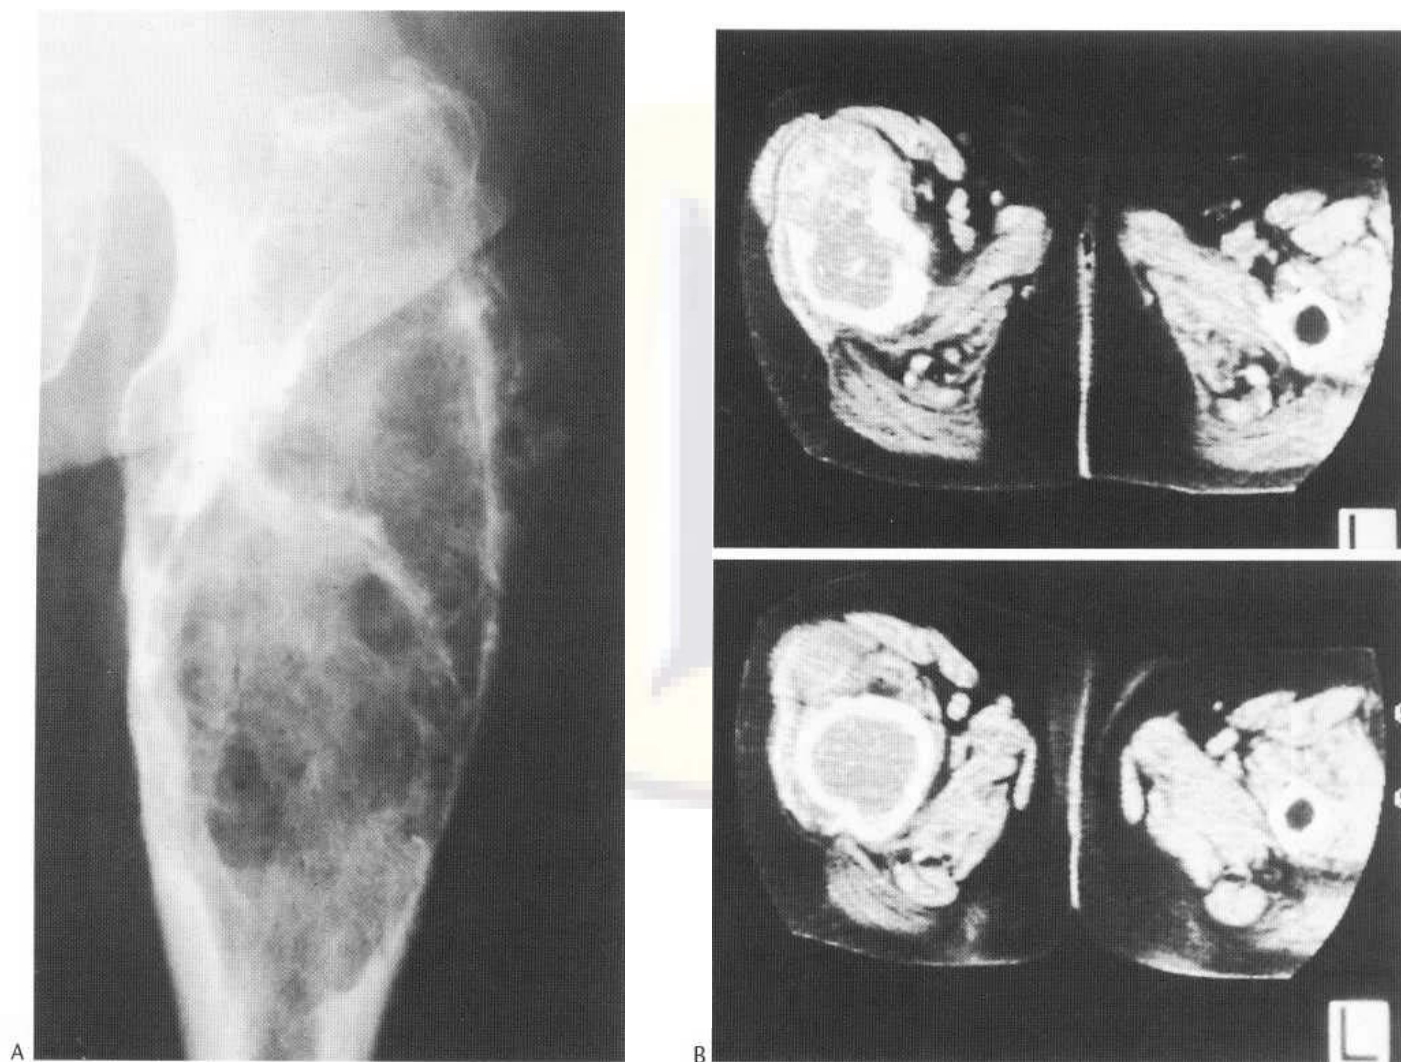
Central chondrosarcoma. (A) The tumour is more aggressive than that in Fig. 39.57, and has extended into soft tissues. This is confirmed by CT (B), showing extension anterior to the femoral shaft. Calcification is present both in the soft-tissue mass and within the shaft lesion.
